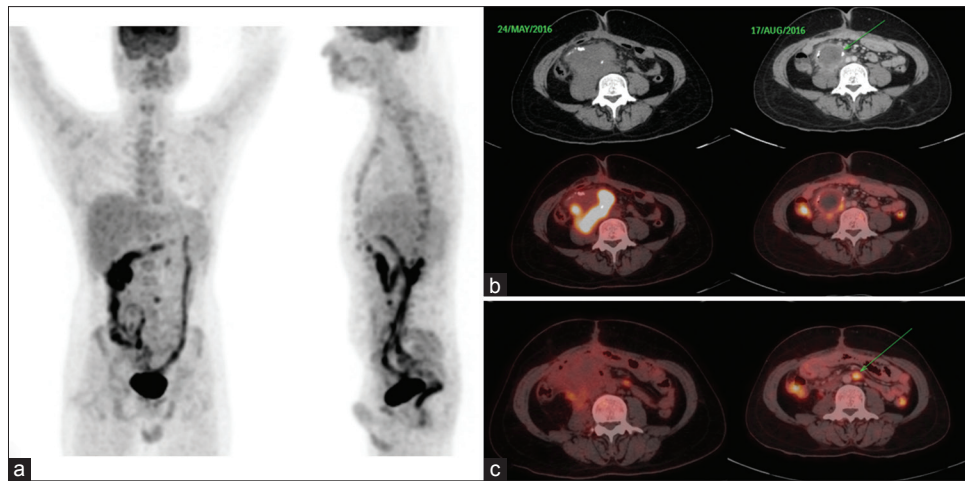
Follow up Wholebody 18F-FDG PET/CT 3 months post completion of ATT; anterior and lateral MIP images (a) demonstrated regression of the soft tissue mass in terms of size and metabolic activity surrounding the transplanted pancreas. Comparative axial CT and fused PET/CT images performed before and after 3 months ATT (b) demonstrated the organization of the soft tissue mass into a well defined peripherally enhancing collection (green arrow) measuring $7.1 \times (\text{CC}) 3.7 (\text{AP}) \times 3.8 (\text{TR})$ cms showing peripheral curvilinear wall calcification and pockets of air [SUVmax: 8.5, previously 15.1]. (c) Multiple enlarged mesenteric nodes with largest one showing FDG uptake (SUV max 5.7, previously 4.5) measured 1.6×0.6 cm (green arrow). Imaging feature suggested partial response to treatment (ATT)
